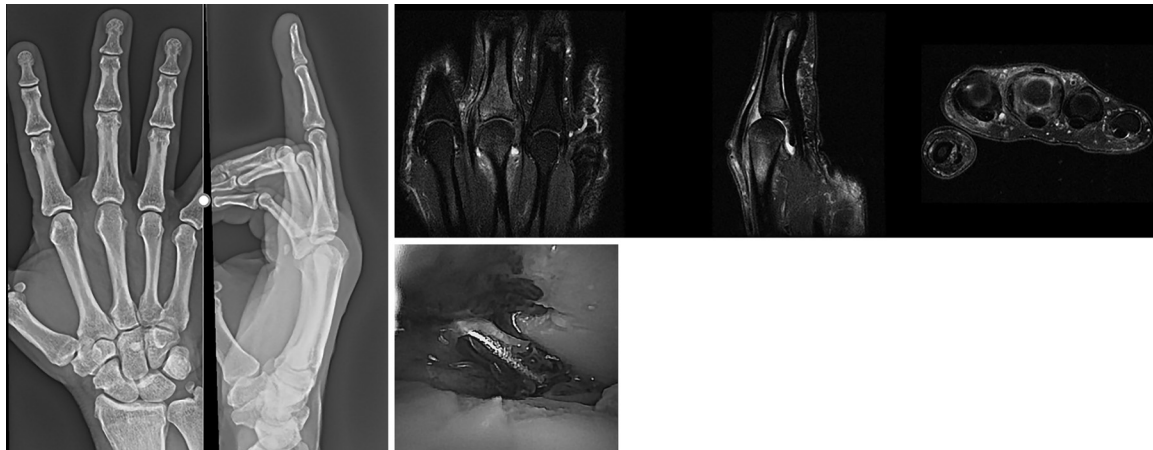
The case of a 62-year-old patient with psoriatic arthropathy. (A) Anteroposterior (AP) and lateral radiographs of the right hand revealing unremarkable findings within the right long MCPJ. (B) MRI reveals joint effusion and mild synovitis. (C) Arthroscopic findings demonstrating profuse synovitis and articular degeneration.
